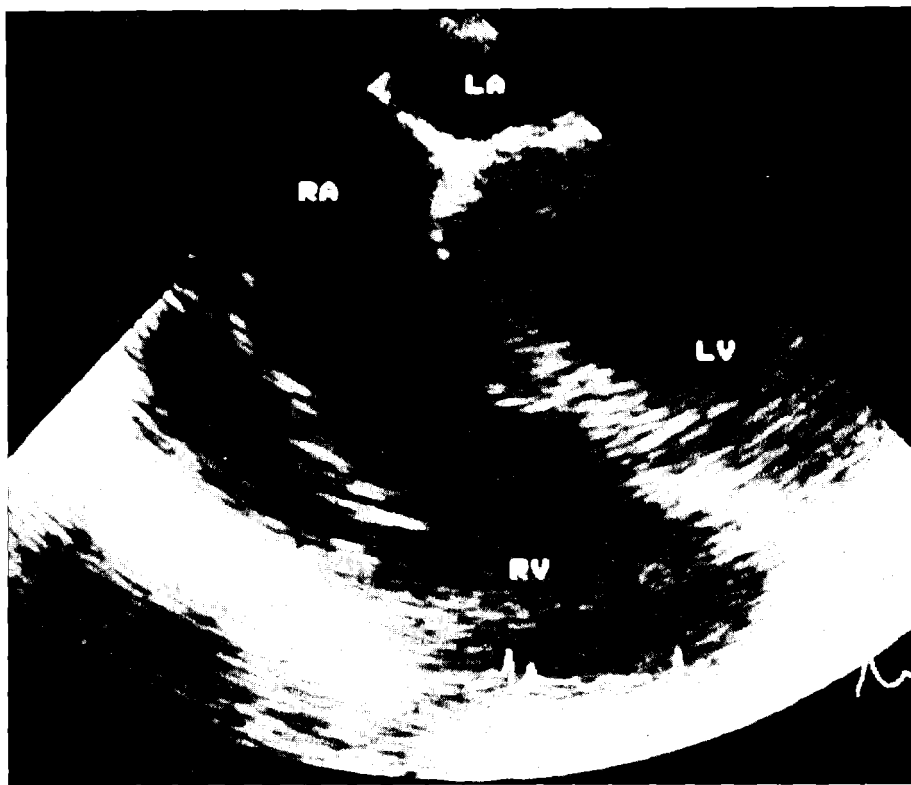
Transesophageal four-chamber view in a patient with Ebstein's anomaly of the tricuspid valve. Tethering and apical displacement of the septal leaflet of the tricuspid valve is readily identified. However, the assessment of the precise morphology of the subvalvar apparatus is limited due to the great distances from the transducer.
